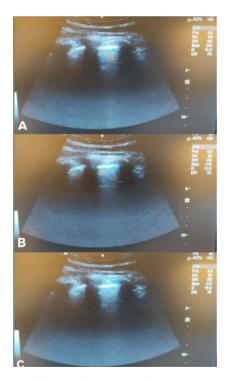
(A), (B), and (C) Lung ultrasound images demonstrating a recovery pattern, with predominance of A-lines and few residual B-lines, indicative of progressive resorption of interstitial edema.
